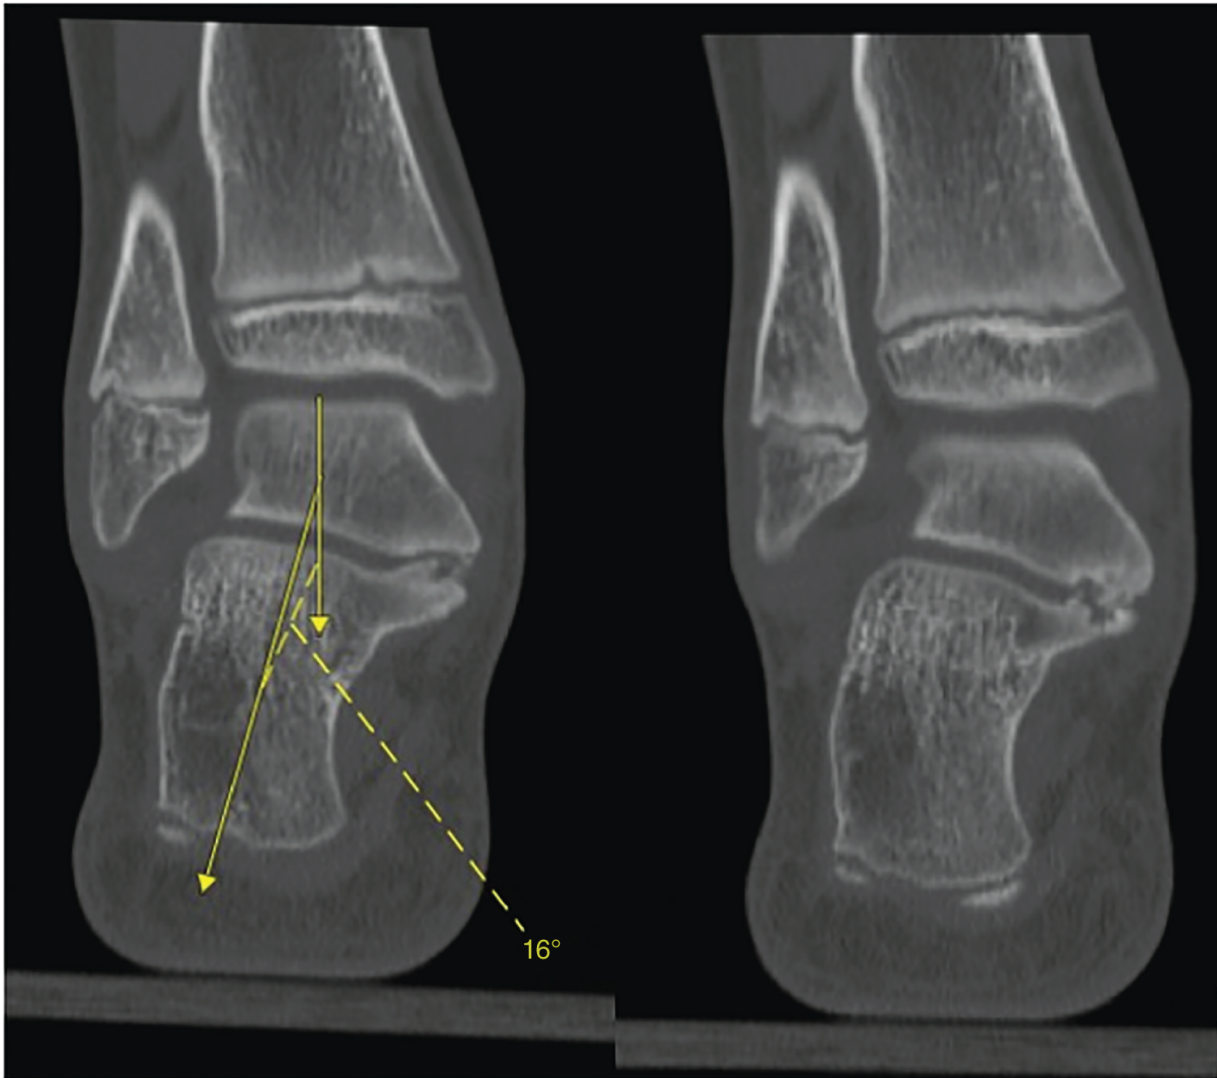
Preoperative CT scan demonstrating an osseofibrous middle facet TC coalition with a surface area measuring 30%. Hindfoot valgus measures 16°. The posterior facet is maintained, although is thin relative to the ankle joint. Source: Joseph Fox, Maryse Bouchard.
